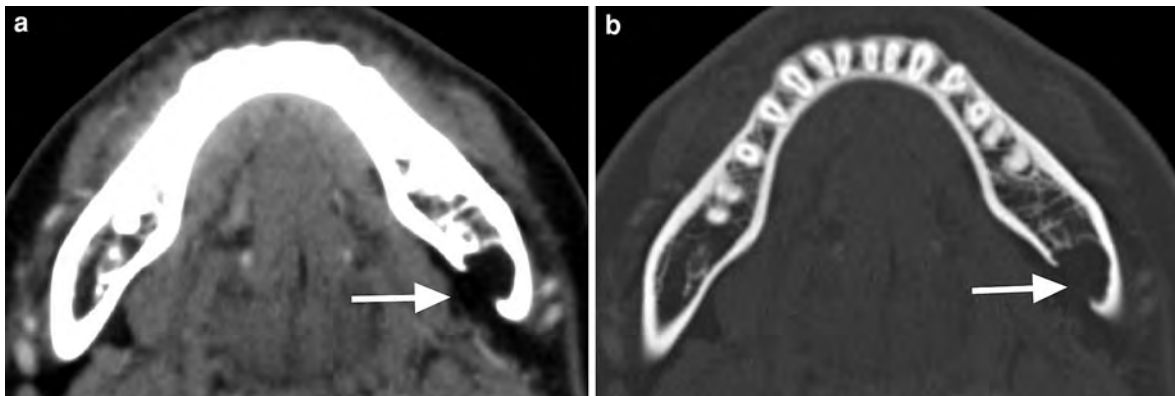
Intrinsic variant on the lingual side of the left mandible in a 25-year-old male without any clinical symptoms. a Axial contrast-enhanced CT image shows a bony defect containing fatty tissue in the left mandibular angle (*arrow*).
